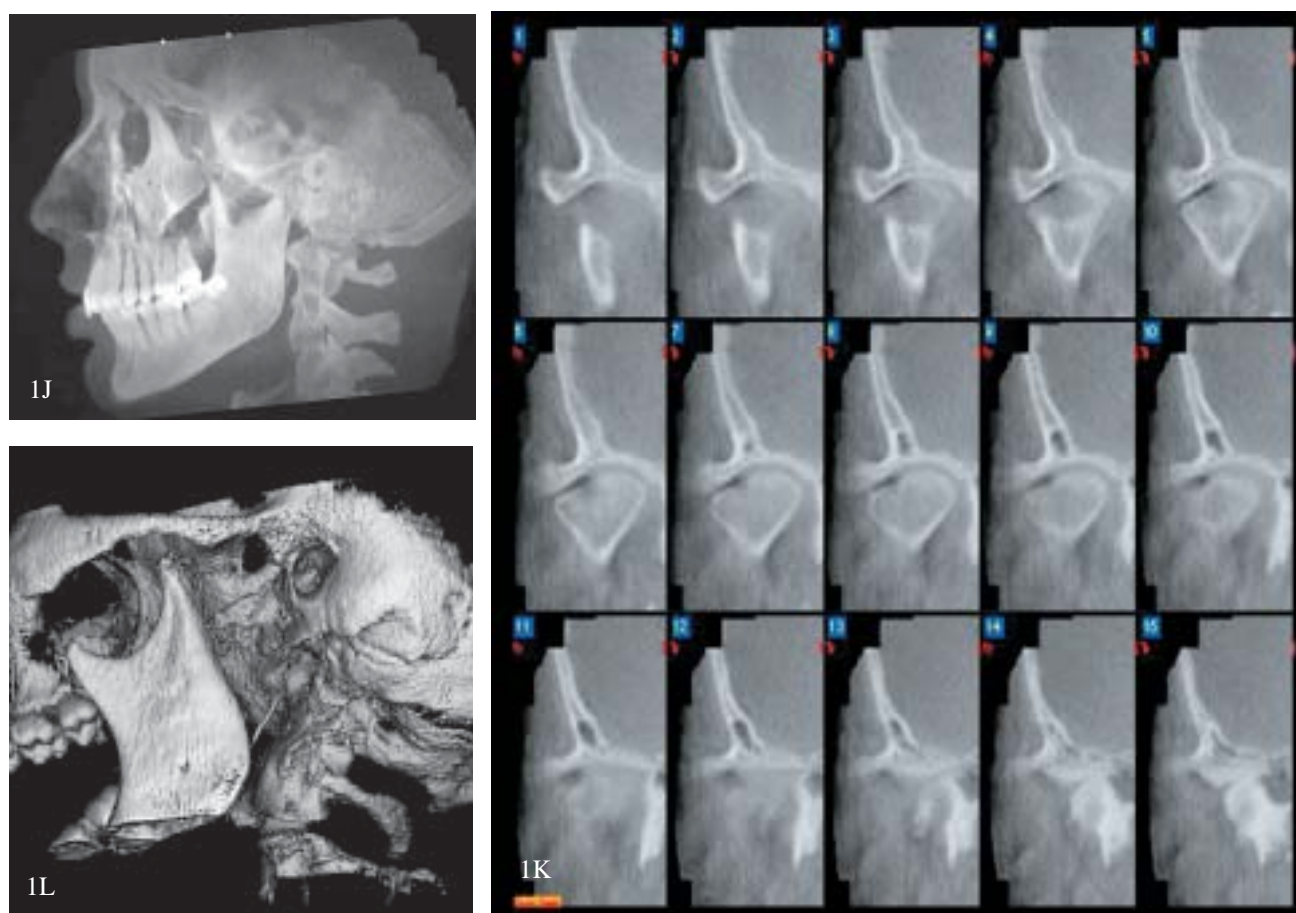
Images taken with a CBCT scanner (courtesy of Aperio Services LLC - Sarasota - FL, USA; and Hitachi Medical System America Inc. - Twinsburg - OH, USA). A) Soft tissue face, B) Maxillofacial skeleton with braces in maxillary posterior dentition, C) soft tissue face and maxillofacial skeleton in the same view, D) image of patient with braces, E) sagittal view of maxillofacial complex, F) coronal view of the posterior dentition, G) image equivalent to bite wing series, H) image equivalent to panoramic radiograph, a 2 mm slice was used, I) and J) image equivalent to traditional cephalograms, but with CBCT both left and right sides can be analyzed and traced separately (an image equivalent to a traditional cephalogram can also be achieved by superimposing right and left structures into a single image), K) a study series on a mandibular condyle, and L) TMJ area.
